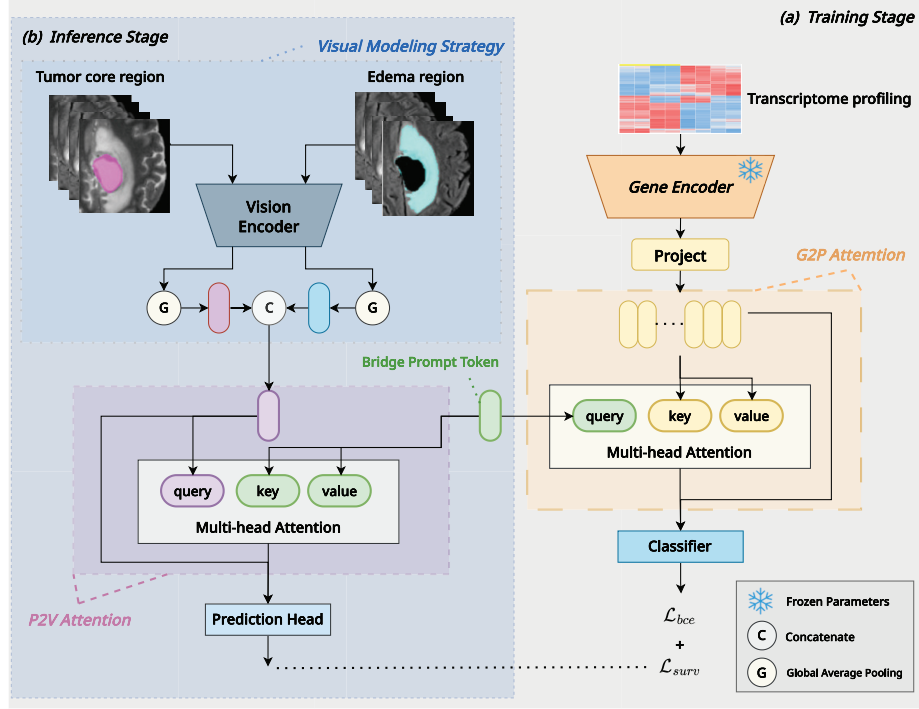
The overview of the our proposed method. The model has different forward propagation processes during (a) training stage and (b) inference stage. The visual modeling strategy in the proposed methods is used to represent glioma MRI images, and the prompt-bridged attention is used to realize multi-modal fusion between transcriptomic profiles and MRI images of glioma patients in the training and enhance visual representations during inference. It is noted that the genetic branch is only used during training. Different optimizer targets are used for the visual branch (left region in this figure) and genetic branch (right region in this figure).
